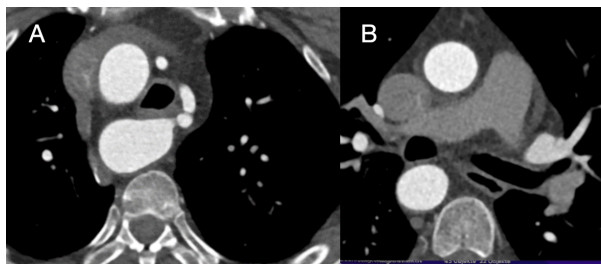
Axial CT images in the arterial phase showing: A: The shift of the ascending thoracic aorta and aortic arch to the midline and the trachea to the left. B: The right-descending thoracic aorta
